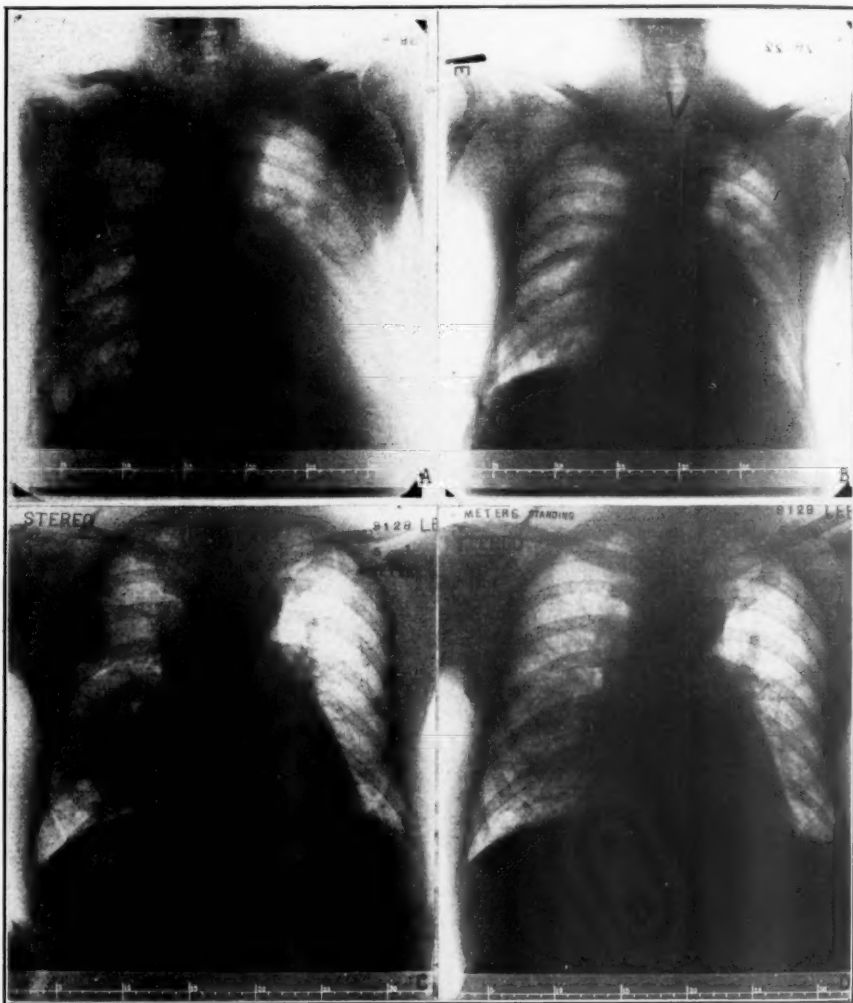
Case II. A. X-ray photograph showing effusion over the right upper lobe occurring during first attack of heart failure. B. Twenty-five days later—interlobar fluid disappeared. C. Eight years later during second attack of heart failure showing a precisely similar effusion. D. Five days after C following recovery from second attack of heart failure.
